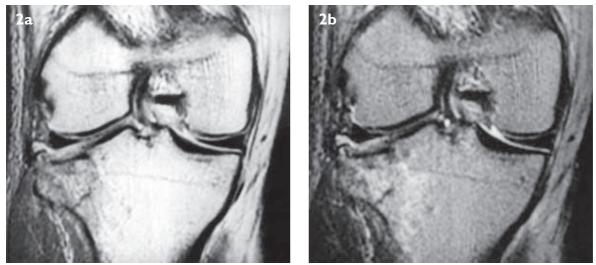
Coronal (a) TI-weighted and (b) T2-weighted MR images of the right knee.
